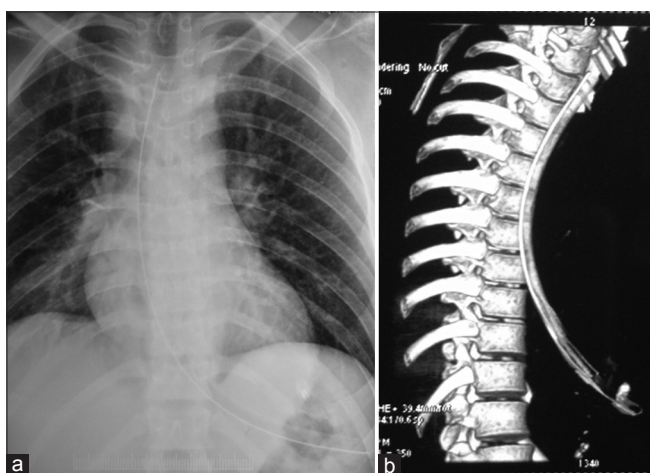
(a) Chest X-ray anteroposterior view showing the endotracheal tube occupying the esophagus with extension into the stomach. (b) Computed tomography chest confirming endotracheal tube in esophagus between vertebral levels T2 to L1
